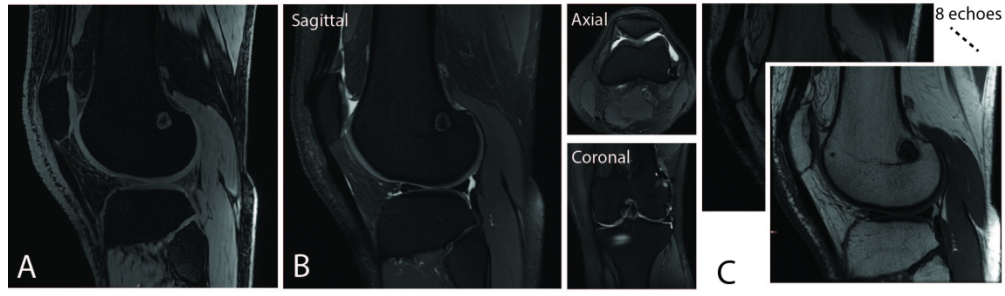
Magnetic resonance imaging protocol. A) Sagittal fast spoiled gradient echo (FSPGR) sequence; B) Sagittal, coronal and axial proton density weight far suppressed spin-echo sequence; and C) Sagittal multi-echo spin-echo sequence
